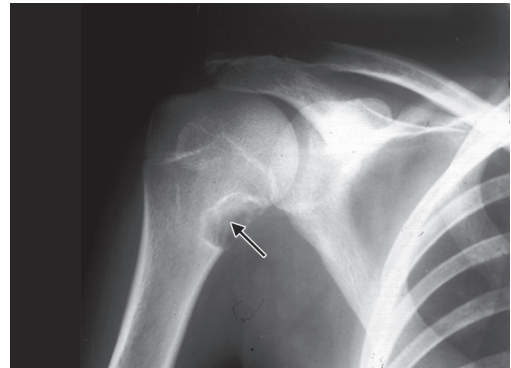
X-ray: fibrous cortical defect (nonossifying fibroma) (proximal humerus)
